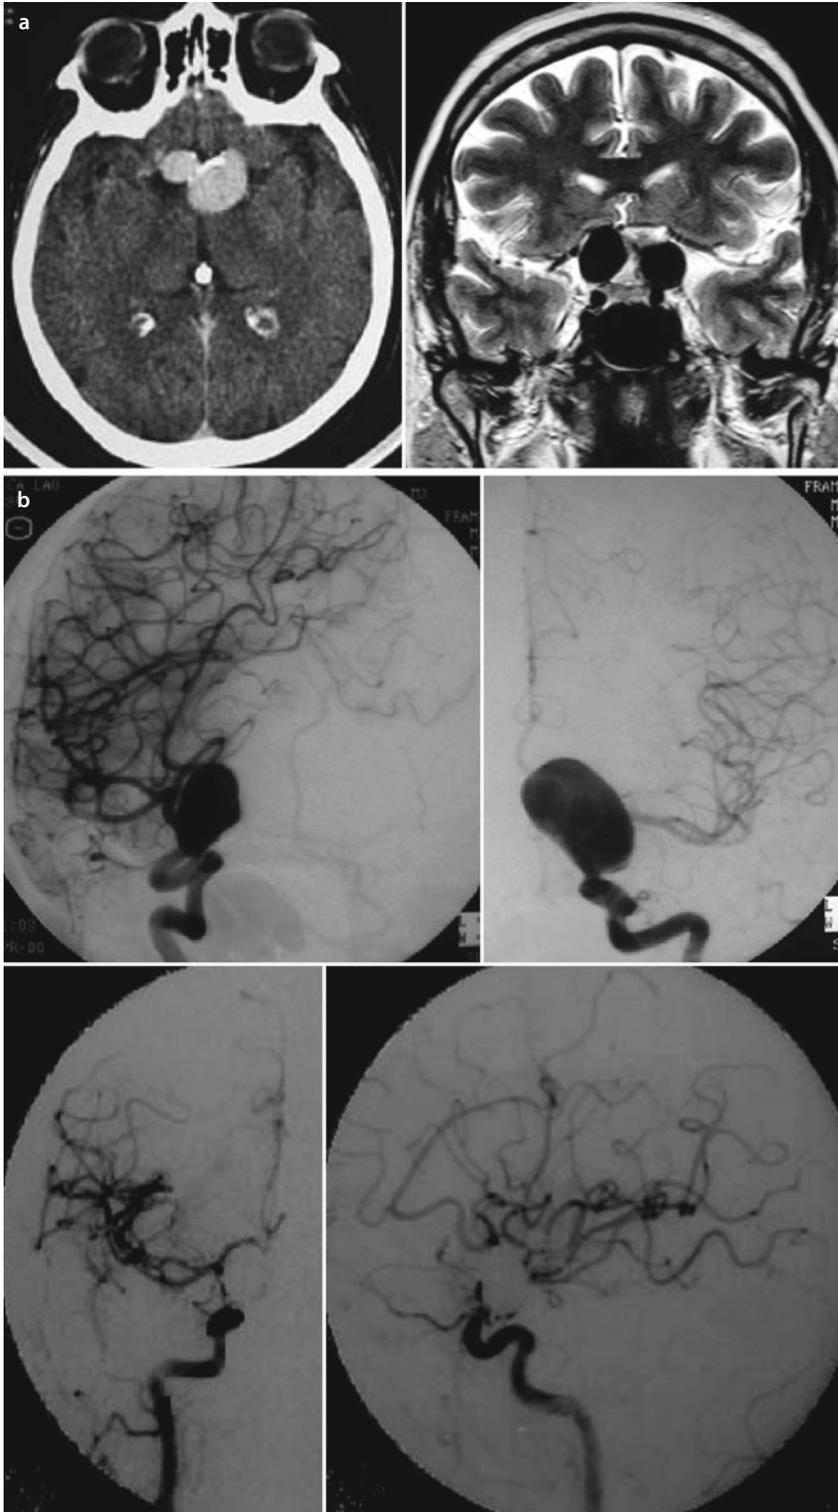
A 55-year-old lady had progressive bilateral visual loss. (a) On March 2000, axial CECT and coronal T2W MRI images show bilateral supraclinoid ICA aneurysms, with the left GIA and right very large aneurysm extending into the suprasellar cistern and compressing on optic chiasma. (b) On April 2000, both the aneurysms were treated with coiling at an outside institution with a stretched coil in the right proximal ICA
